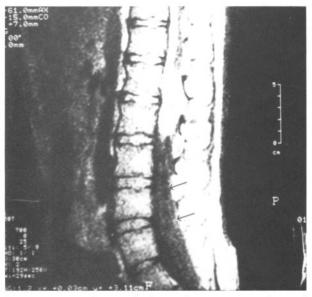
MRI scans showing the dermoid tumour at L1 and L2, and the filum terminale (arrows)
